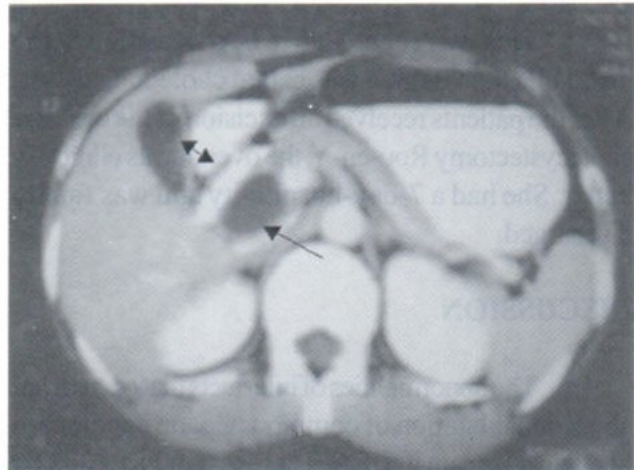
CT of upper abdomen reveal gallbladder (↔) and cyst at head of pancreas (→)
